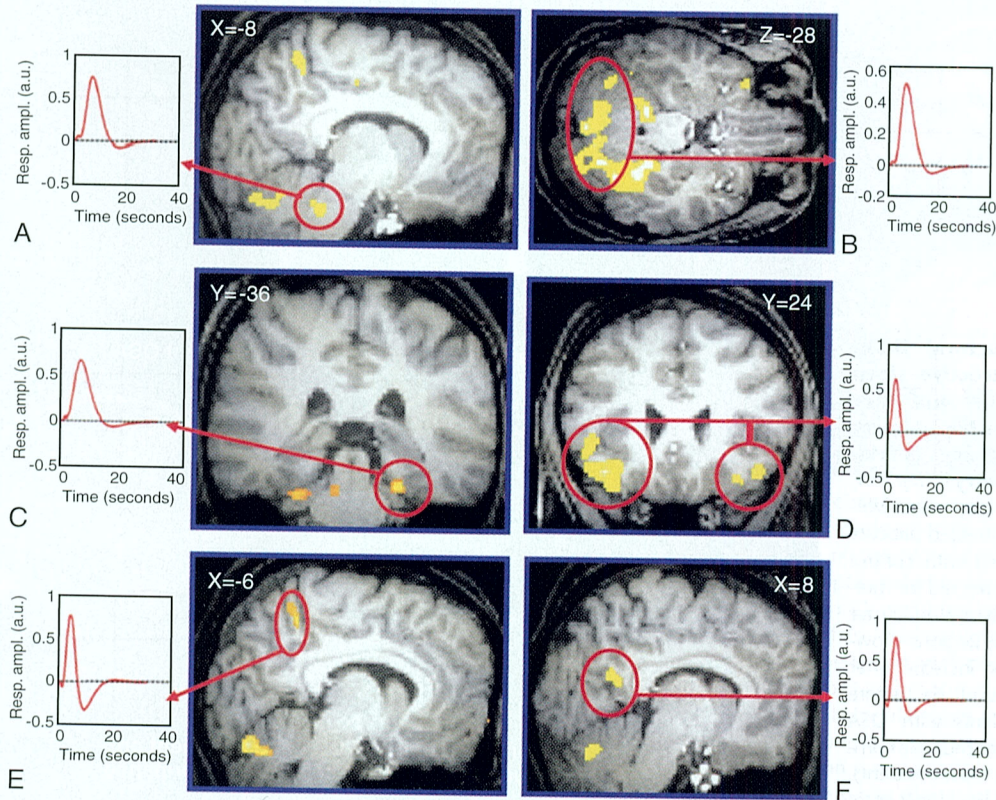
Functional neuroanatomy of sleep slow waves (functional magnetic resonance imaging). Brain responses associated with slow waves, as compared to the baseline brain activity of non-REM sleep. Brain responses were significant at $P < .05$, corrected for multiple comparisons. Activations were located in the pons (A), cerebellum (B), parahippocampal gyrus (C), inferior frontal gyrus (D), precuneus (E), and posterior cingulate gyrus (F). The *side panels* show the time course (in seconds) of fitted response amplitudes (in arbitrary units) during slow waves in the corresponding *circled* brain area. All responses consisted of regional increases of brain activity. (Modified from Dang-Vu TT, Schabus M, Desseilles M, et al. Spontaneous neural activity during human slow wave sleep. *Proc Natl Acad Sci U S A*. 2008;105:15160-15165. Copyright 2008 National Academy of Sciences, U.S.A.)
